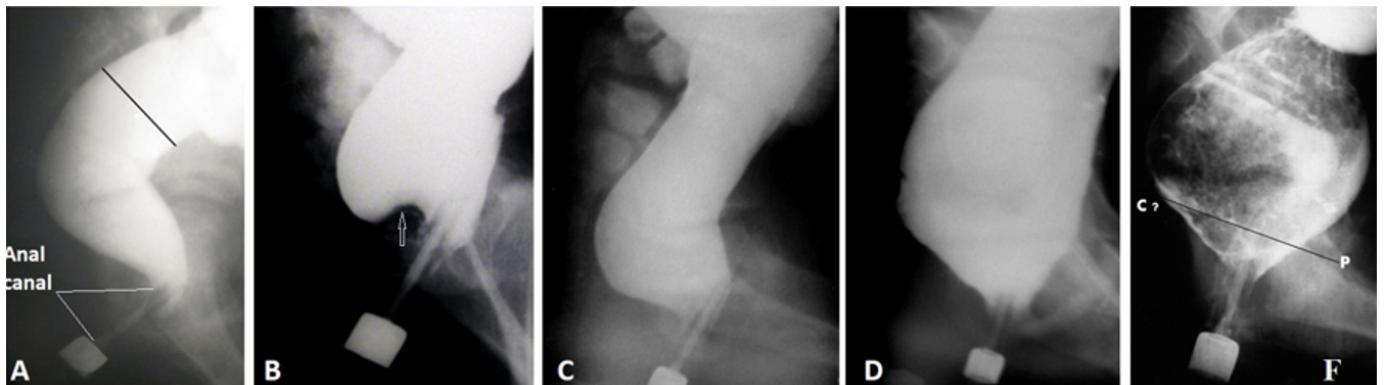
Lateral radiographs of the anorectum in patients with FM at different stages of megacolon development and PRM damage. (A) In a 13-year-old patient without constipation, the vertical and horizontal branches of the rectum are determined. On radiographs B-F, the horizontal branch of the rectum is absent due to rectal dilatation. (B) A 3-year-old patient has concavity at the base of the rectum (arrow) because of PRM edema. It gives the impression of an elongation of the anal canal. This is the initial phase of FM. (C) In a 4-year-old patient, the penetration of barium into the upper part of the anal canal behind the enema tip is determined due to the weakness of the PRM. (D) In a 12-year-old patient, a sharp expansion of the rectum is accompanied by the same sharp shortening of the anal canal due to insufficiency of PRM. This is a picture of the descending perineal syndrome, which is often characterized by fecal incontinence. (F) The mechanism of anorectal obstruction is shown. The peristaltic wave creates a large force to push a large diameter fecal stone through the anal canal, through which is not able to pass this stone. As a result of the efforts of the rectum, the stone bougienages and stretches the muscles of the pelvic floor, which leads to stretching and weakening of the PRM.
